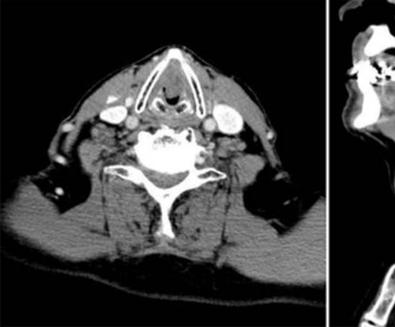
Axial and sagittal CT: well delineated tumour mass in the larynx and critical airway.
